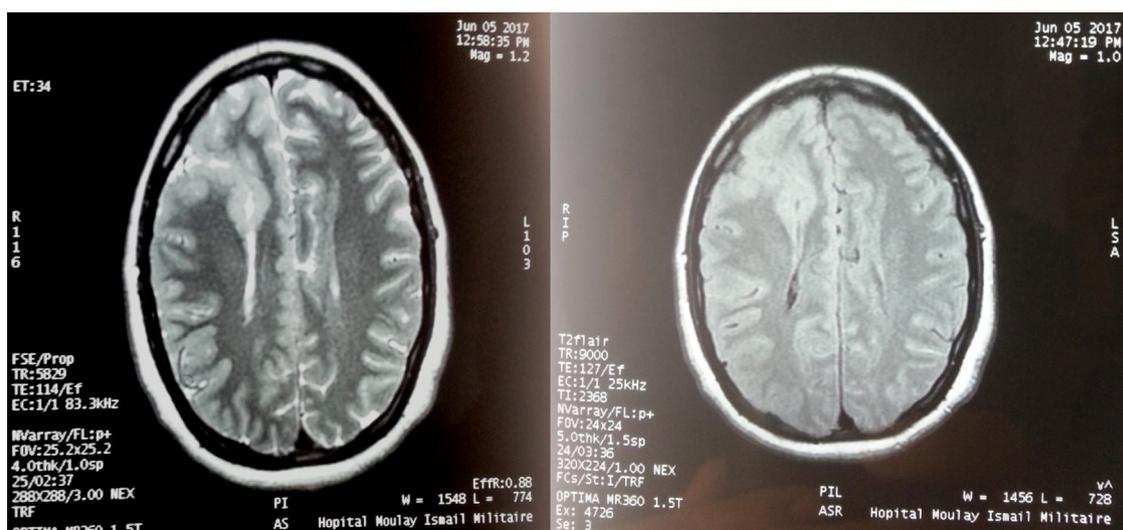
MRI images showing unilateral right schizencephaly.
